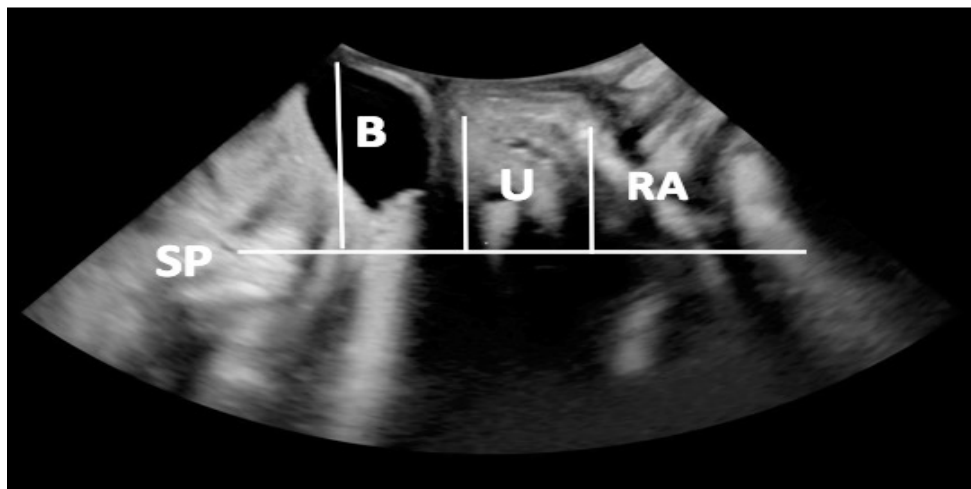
Translabial ultrasound imaging in the mid-sagittal image on Valsalva manoeuvre. Orientation: top of the image is caudal; bottom is cranial, left of the image is ventral and right is dorsal. Pelvic organ descent is measured with the most dependent part of the bladder, the leading edge of the uterus and the most caudal part of the rectal ampulla and/or small bowel, from a reference line drawn horizontally through the infero- posterior margin of the symphysis pubis. SP = symphysis pubis, B = bladder, U = uterus, RA = rectal ampulla.
